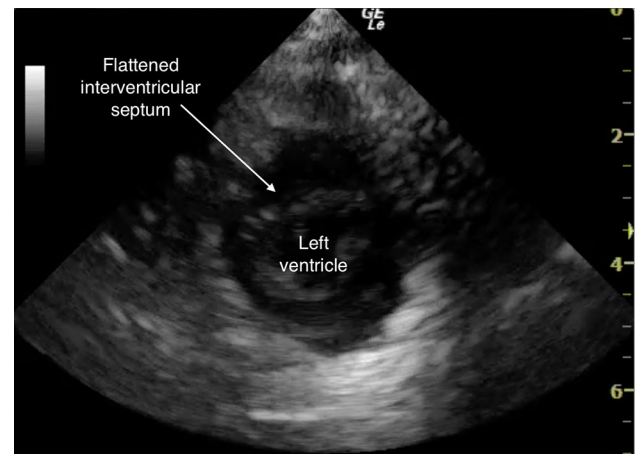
Video Parasternal short-axis view at the mid-papillary level. Displacement of the interventricular septum (IVS) into the left ventricular chamber due to right ventricular pressure overload
